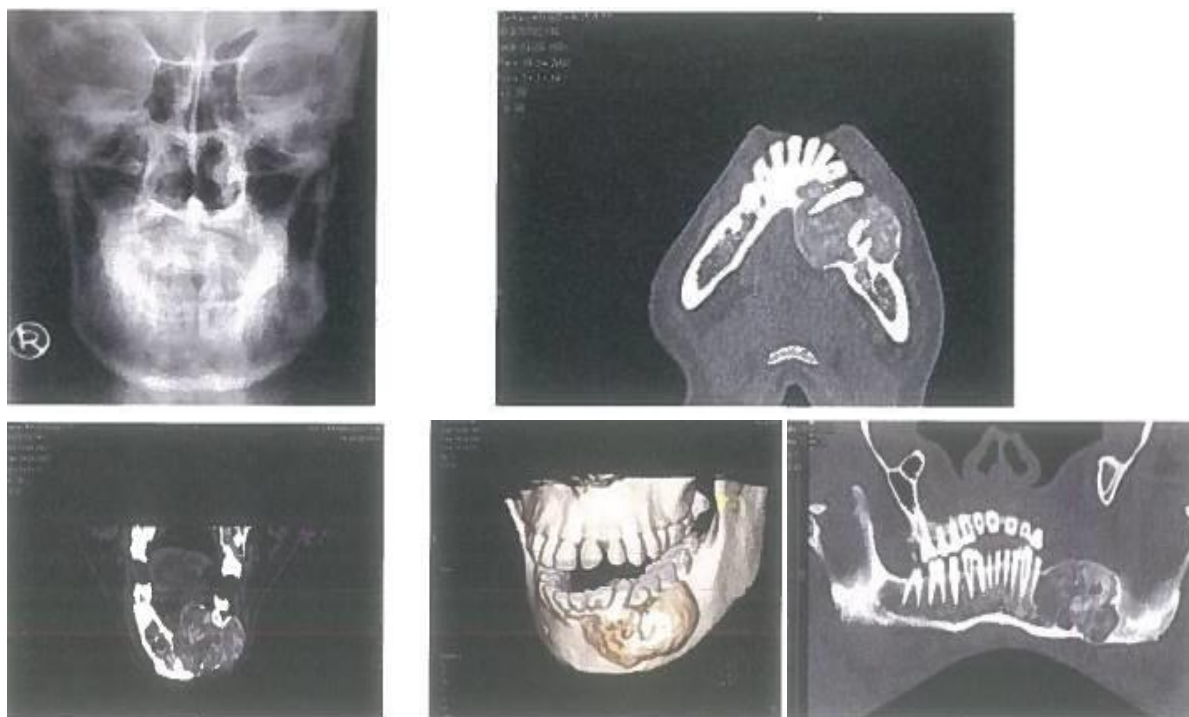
Ossifying fibroma. PA view of the mandible shows lytic lesion in ramus on left side. CT axial, panoramic and VRT image shows well circumscribed mixed radio opaque radiolucent lesion with internal calcifications.
